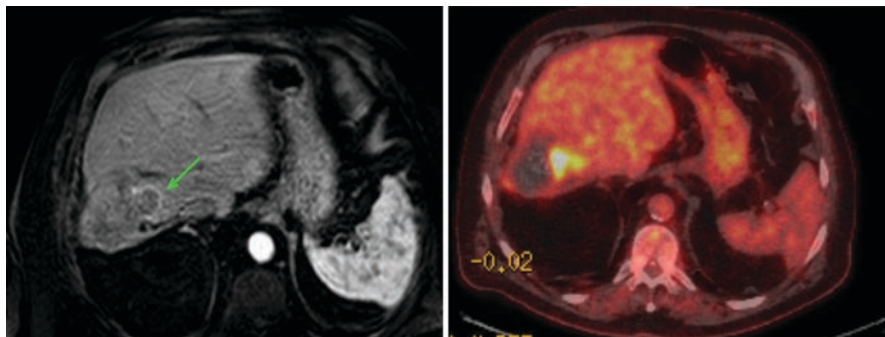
A thin rind of enhancement on arterial phase MRI typically indicates hyperaemia, but since this appearance was focal and had settled around the rest of the ablation margin, residual disease was suspected, as proven on PET CT
